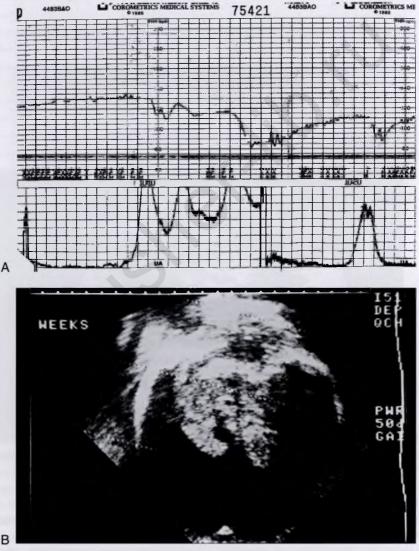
(A) CTG: unsteady baseline but with plenty of fetal movement; (B) ultrasound scan showing the fetus with holoprosencephaly.
